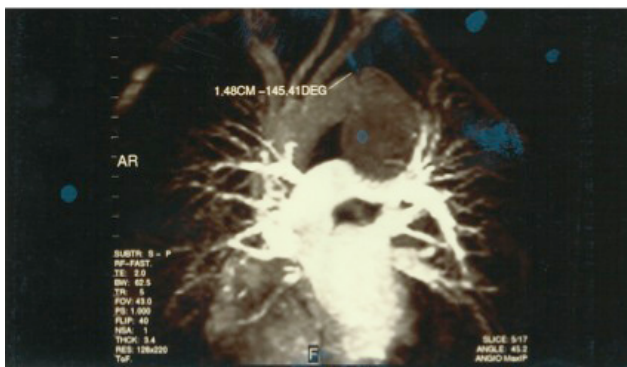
Angio MRI: presence of pseudo-aneurysm of the descending thoracic aorta compressing the bronchus of the left and probably the left recurrent nerve. At the level of the origin of the descending thoracic enjoying a break from the intima closed chest trauma.
